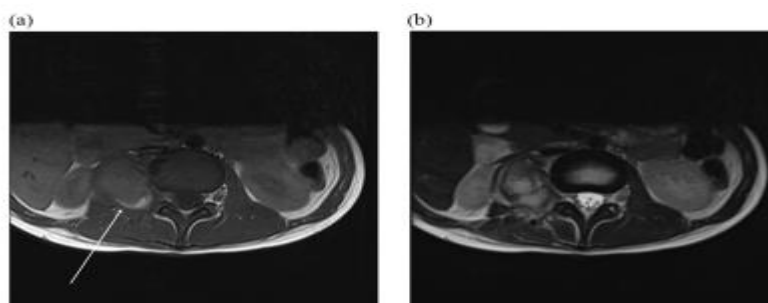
MRI images (a) Axial pre-contrast T1-weighted. (b) T2-weighted
